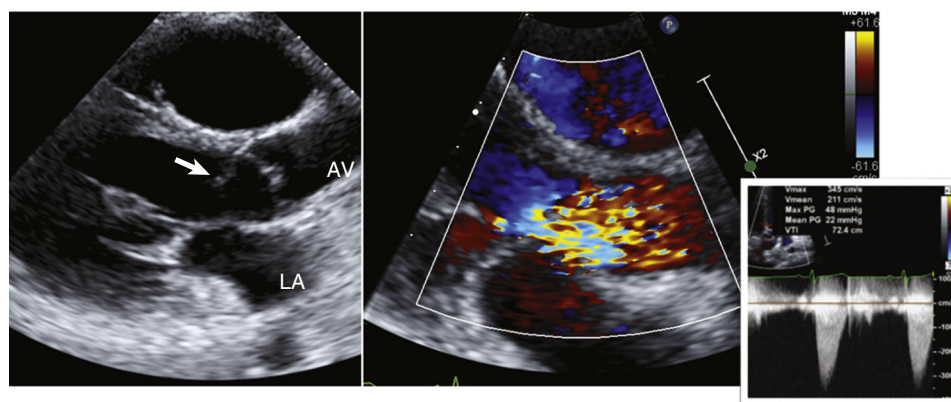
Parasternal long-axis view demonstrating Left, a subaortic membrane (arrow) extending from the anterior mitral leaflet to the septum. The aortic valve (AV) is about to open. LA, Left atrium. Right, color Doppler showing turbulent brisk flow across the membrane. Right inset, CW Doppler showing a peak gradient across the LVOT of 48 mm Hg.
